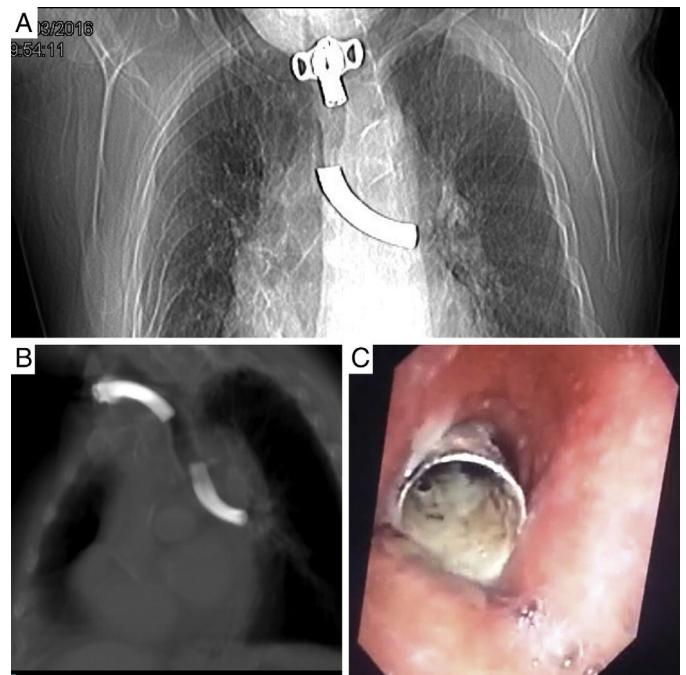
(A) PA chest radiograph. (b) Chest CT without contrast medium. (C) Fiberoptic bronchoscopy image.
